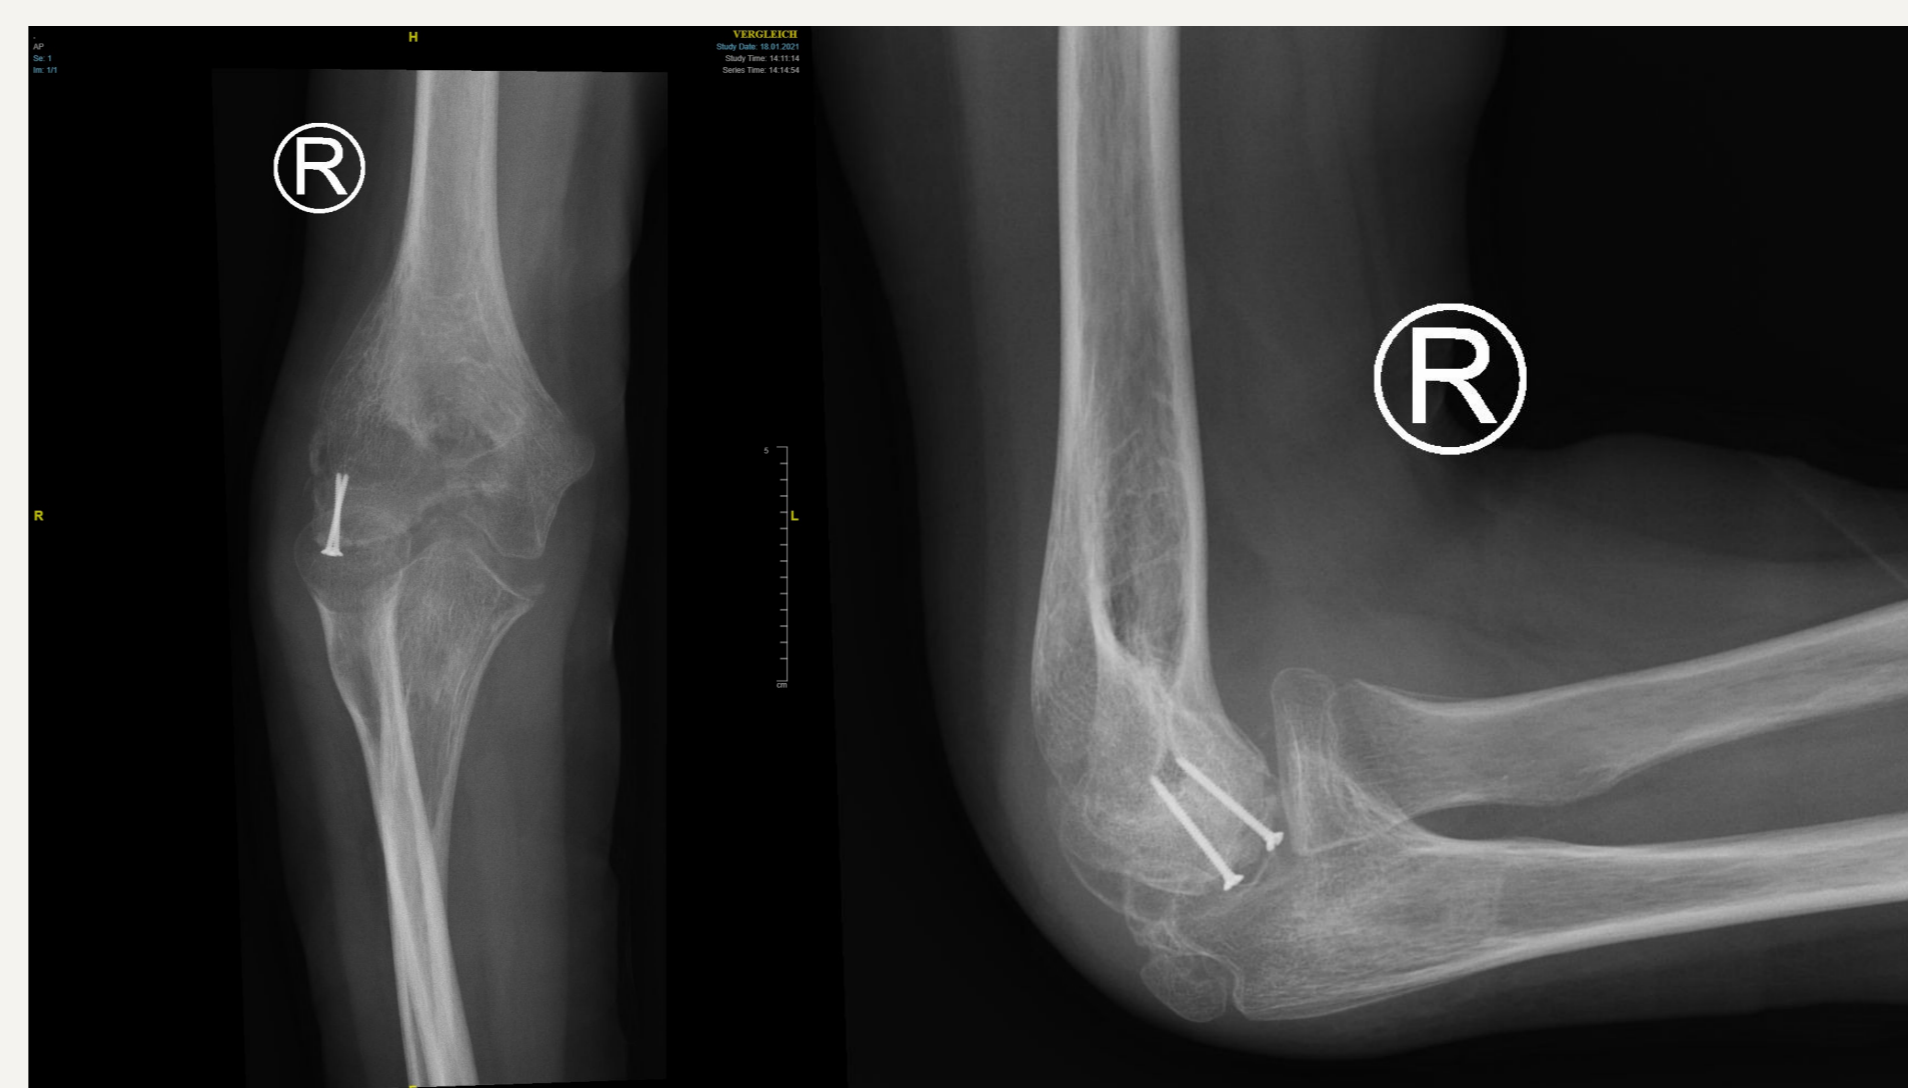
ap/lateral radiograph, 6 weeks postoperatively, slight deformity of the humeral capitulum and olecranon, demineralisation of the humeral trochlea, of the radial capitulum and olecranon
